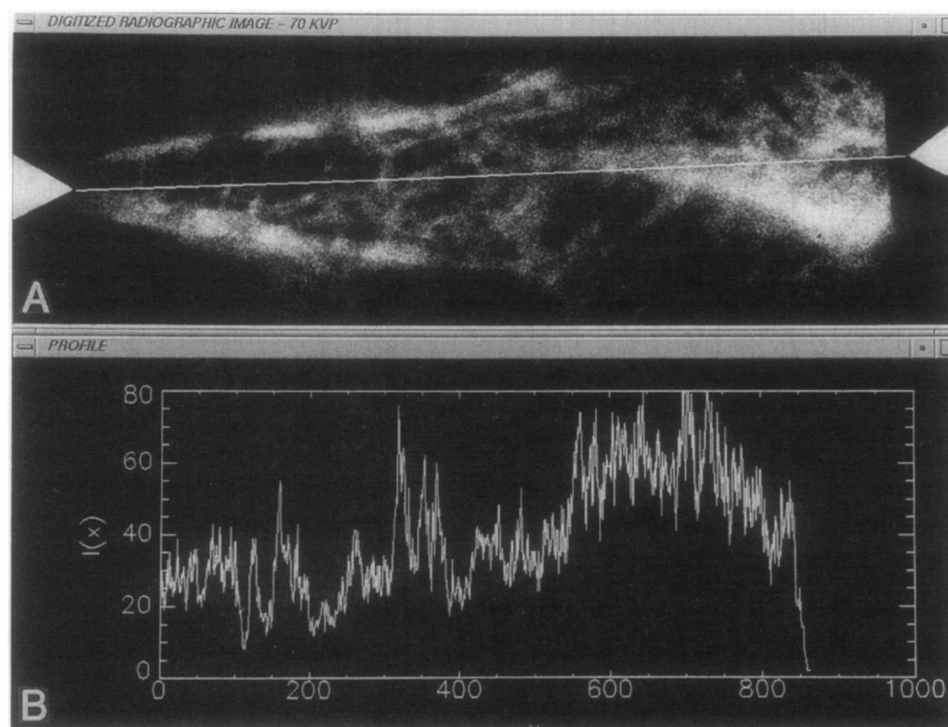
Representative human maxillary alveolar radiographic image. A, Digitized image with the bony profile (scan line) selected between points on lead markers. B, Corresponding profile intensity value, $I(x)$, plot.
